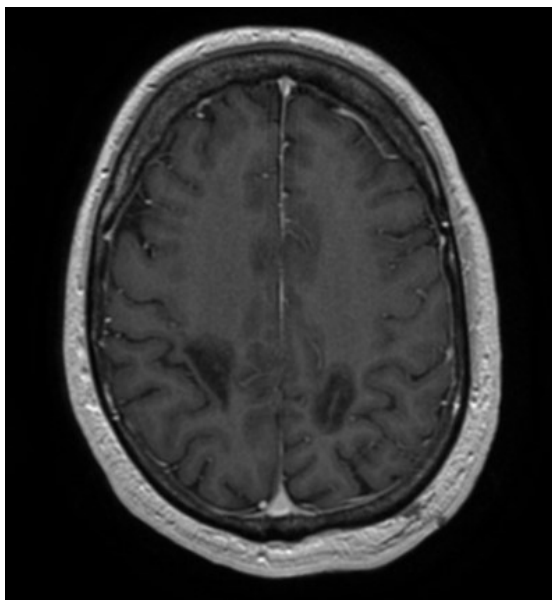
MRI images in T1 post contrast sequence taken three months post treatment
